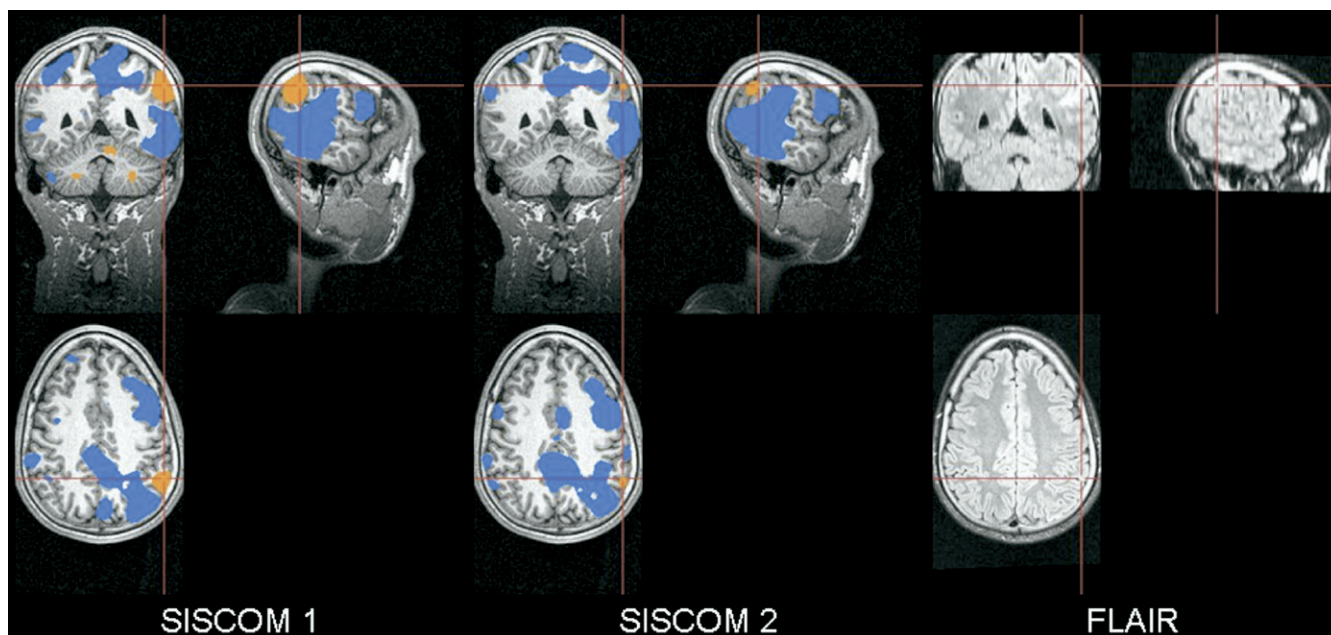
Localizing postictal SISCOM. Threshold: $>+2$ SD: orange, <-1 SD: blue. Patient had refractory partial epilepsy as the result of a focal dysplastic lesion in the left parietal lobe, which was visible as a hyperintense lesion on FLAIR (red cross). The patient had 2 ictal SPECTs. The first injection was given 5 seconds after the end of a complex partial seizure that lasted 16 seconds, and the second 11 seconds after one that lasted 25 seconds. The largest and most hyperintense cluster partially overlapped the focal dysplastic lesion in both studies (red crosses in SISCOM 1 and 2). Notice the large areas of hypoperfusion surrounding the ictal onset zone, which is not seen in ictal SISCOMs, which is consistent with the hypothesis of “surround inhibition.”⁴³ All images were coregistered.
